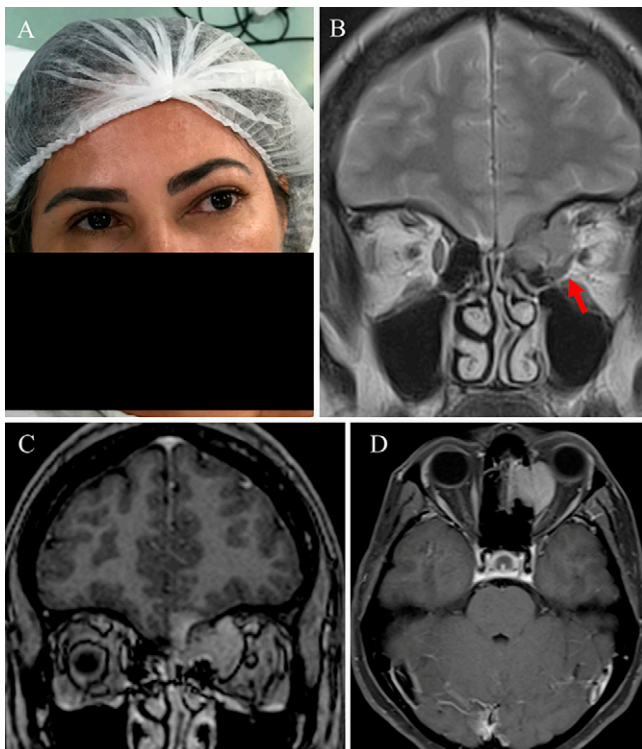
Photograph (A) showing the patient's discrete proptosis on the left side with a tendency to lateral ocular deviation. T2-weighted MRI (B) showing an isointense intraorbital lesion with displacement of rectus medialis muscle (red arrow). Coronal (C) and axial (D) contrast-enhanced T1-weighted MRI shows homogeneous enhancement with an evident tricompartmental (anterior skull base, ethmoid, and orbit) lesion suggesting a diagnosis of meningioma.
